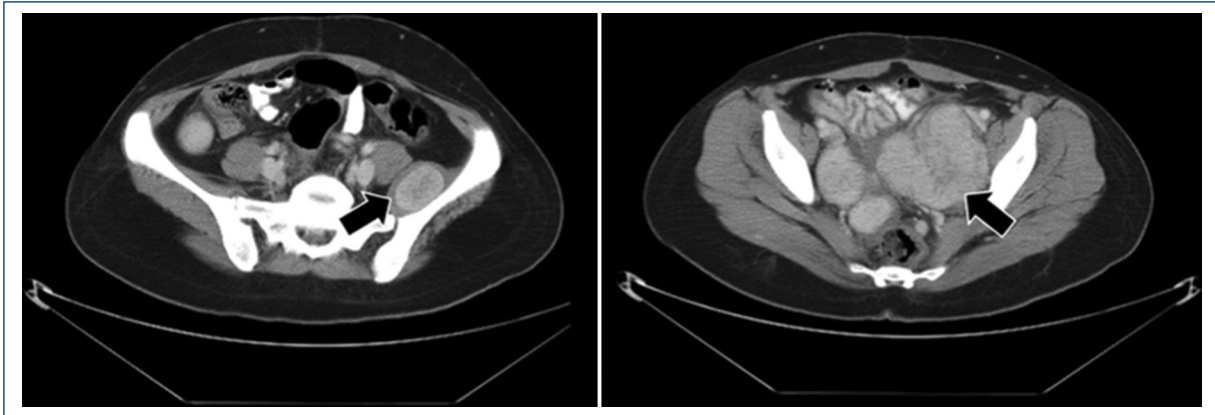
Computed tomography: multiple pelvic heterogeneous nodules.
